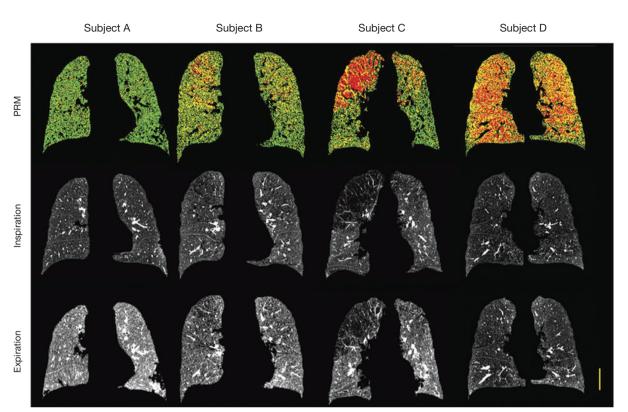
COPD phenotypes identified by parametric response mapping (PRM). The strength of PRM to identify functional small airways disease (fSAD) from emphysema is demonstrated in representative coronal PRM images with corresponding inspiratory and expiratory CT scans from four individuals with varying GOLD status. From the three classifications, normal lung tissue is denoted green, fSAD is denoted yellow and emphysema is denoted red. Yellow scale bar indicates 5 cm. Reproduced with permission from reference (130). COPD, chronic obstructive pulmonary diseases.
